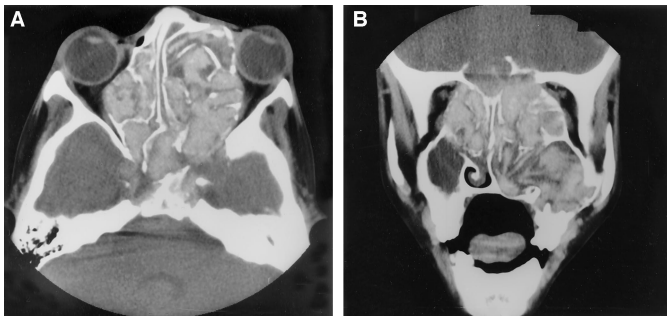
A, postcontrast axial CT scan showing a contrast-enhancing mass, which is producing bone destruction and extending the orbital cavities more on the left side. B, postcontrast coronal CT scan of the same patient, showing bony destruction of the cranial base. This patient underwent fiberoptic endoscopic sinus surgery, was treated with orally administered itraconazole therapy for 12 months, and had a good recovery (GOS score, 5).
